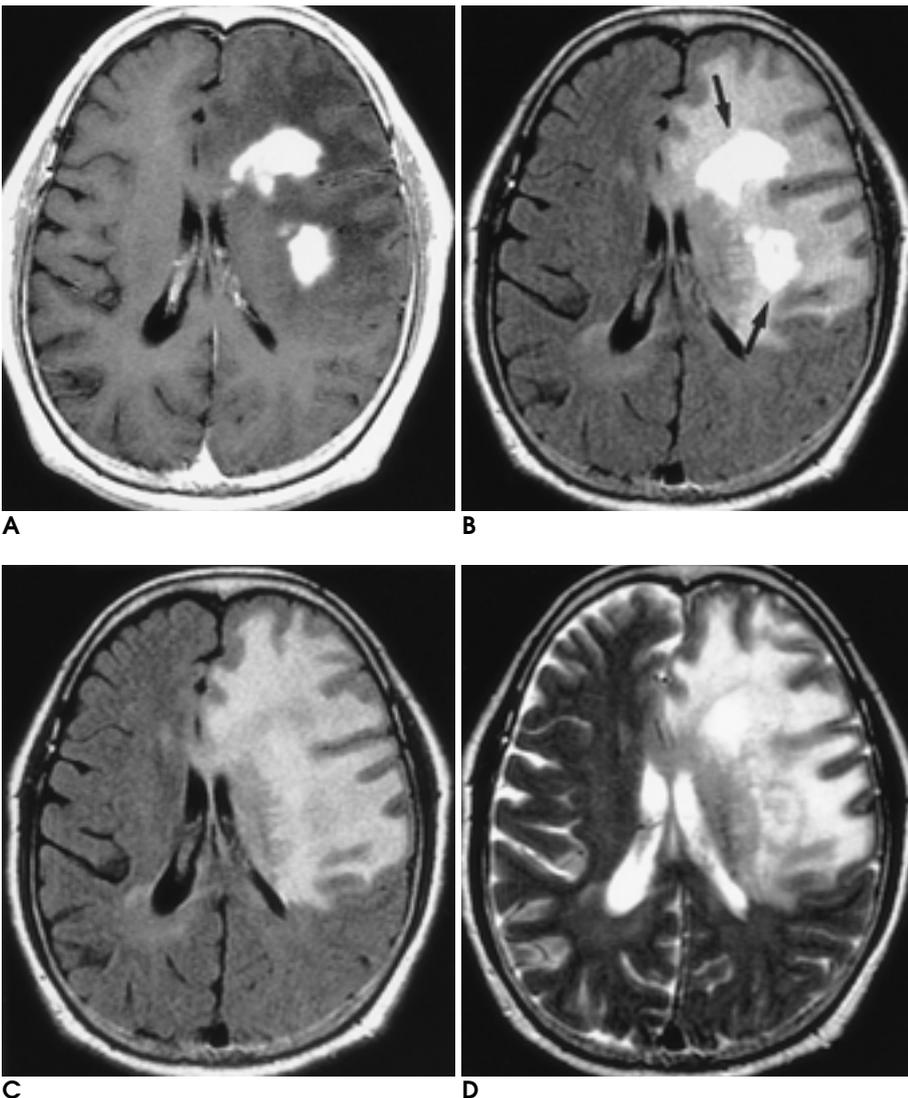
A 55-year-old woman with lymphoma. Contrast-enhanced T1-weighted (A) and fast FLAIR (B) images show strongly enhancing masses in the left frontal lobe (arrows). Contrast-enhanced Fast FLAIR image shows clear distinction between tumor and surrounding edema. Fast FLAIR (C) and T2-weighted (D) images show poor conspicuity and indistinct delineation of tumor because the high signal intensity of tumor is similar to surrounding edema. Although the conspicuity of tumor is best on contrast-enhanced T1 weighted image, contrast-enhanced fast FLAIR shows better conspicuity of tumor than fast FLAIR or T2-weighted image.
